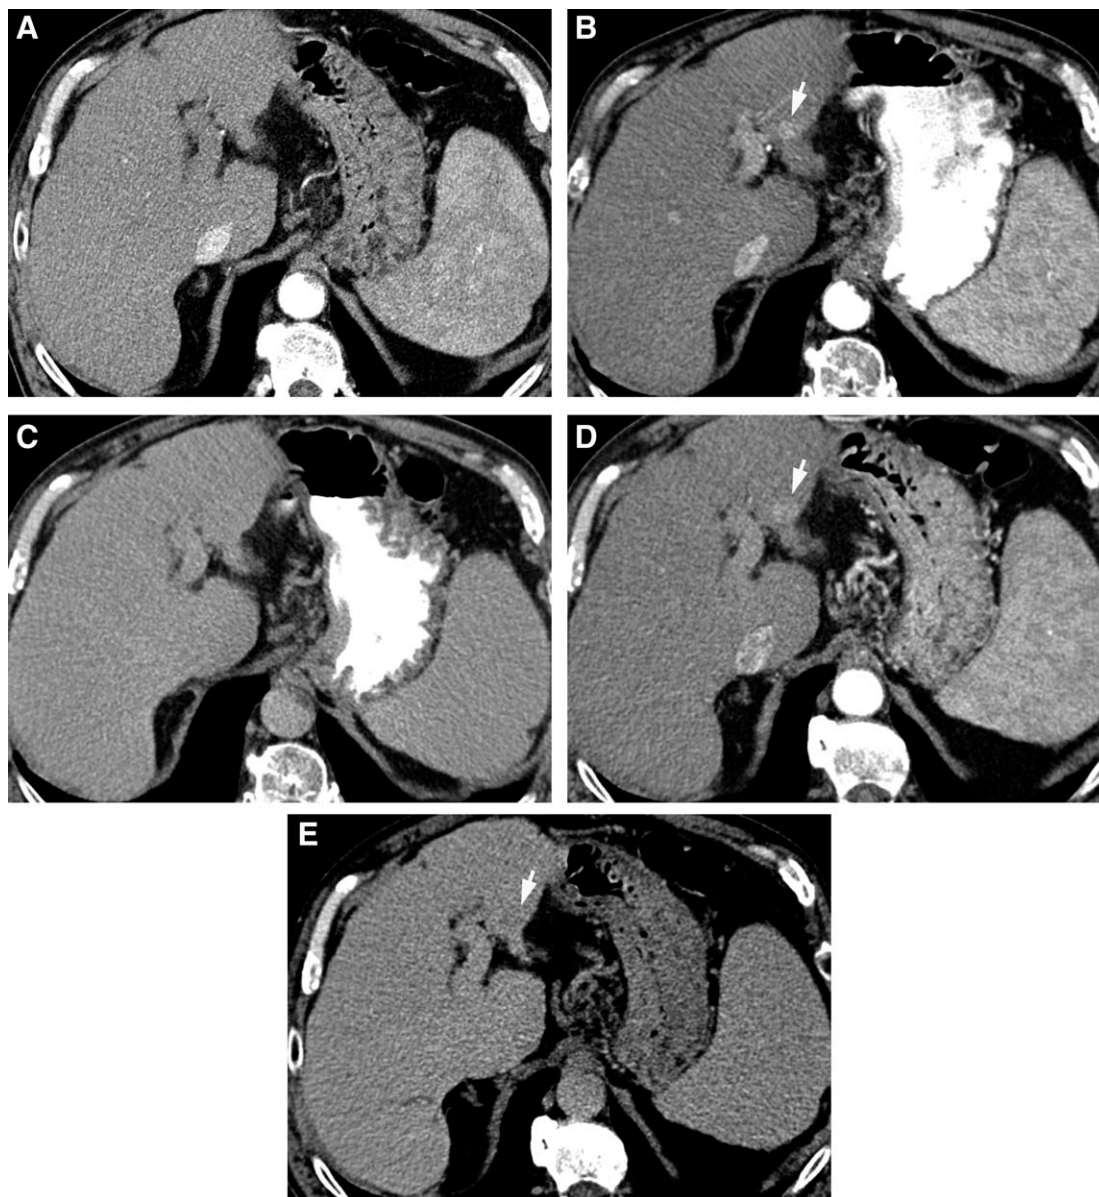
Detection of HCC recurrence after surgical resection. This series of images shows the evolution of a nodule detected during follow-up and how it would be registered as a new tumor site according to conventional RECIST or as per mRECIST.<sup>23,28</sup> Panel A represents the non-contrast CT scan phase without an evident nodule. During the arterial phase (panel B) it is feasible to identify a 10 mm nodule located in the left hepatic lobe. Panel C exposes the pattern at the equilibrium phase where no washout is evidenced. According to conventional RECIST, this could be registered as tumor recurrence (or progression if treated by ablation/chemoembolization or with systemic therapy). By contrast, to register it as such using mRECIST it is needed to follow-up the patient until detecting the appearance of washout. At that point the new tumor site is confirmed. Panel D shows that after 6 months, the nodule has grown and still exhibits intense contrast uptake in the arterial phase, while also showing washout in the equilibrium phase (panel E). Time of recurrence/progression is that of first detection with both systems, but if follow-up would not have been there because of trial design, it would have been impossible to properly evaluate the data according to mRECIST as some recurrences would never be confirmed.
